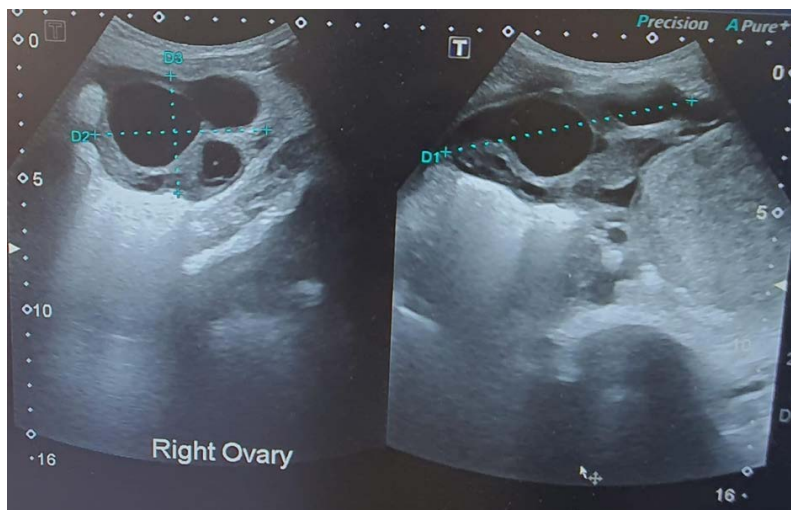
Sonographic evidence of an enlarged ovary with many large follicles in keeping with hyperstimulated ovaries
